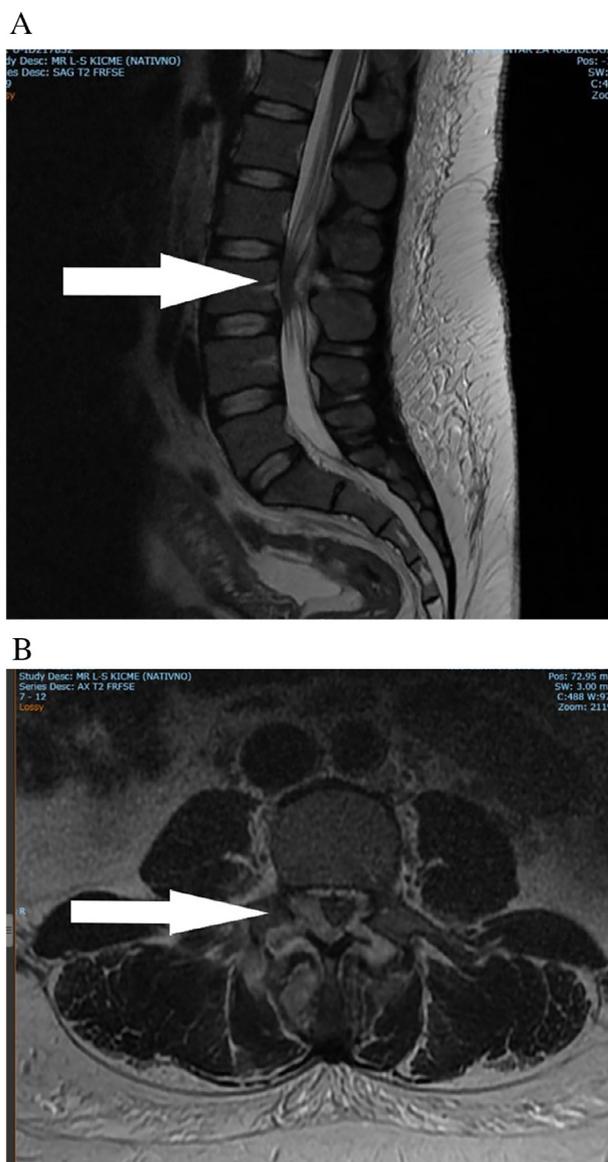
Initial magnetic resonance image of the lumbar spine, 12 days after spinal anesthetic. A: sagittal section, B: axial section. White arrows indicate location of the epidural hematoma
